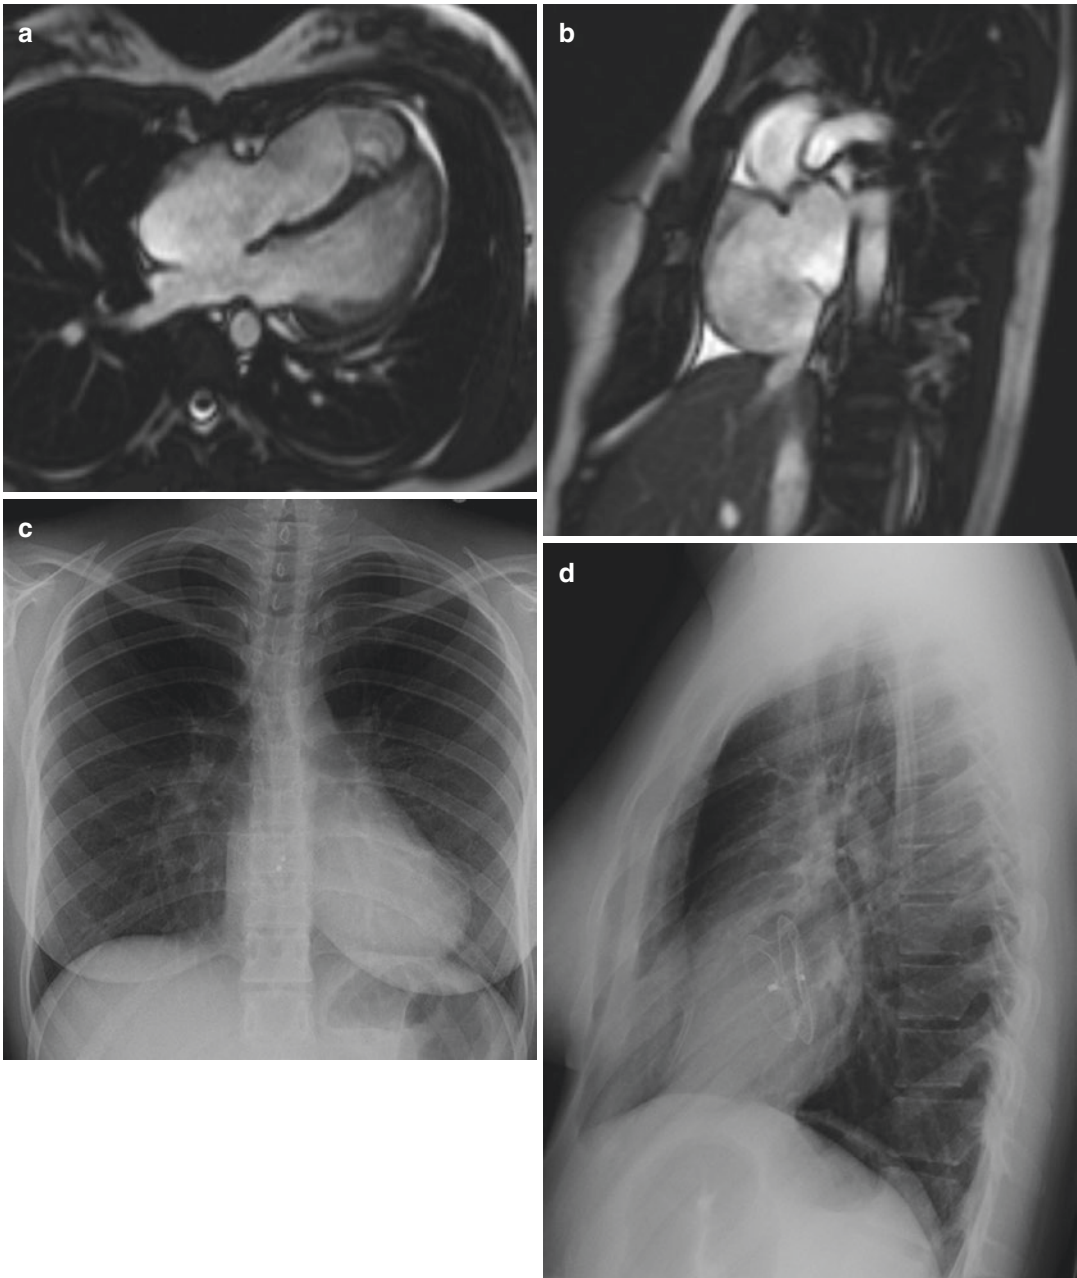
Secundum ASD treated by septal device occluder. Four-chamber view (a) and perpendicular view (b) images of cine TRUFISP MRI sequence demonstrate large secundum ASD. Frontal (c) and lateral (d) radiographs obtained
